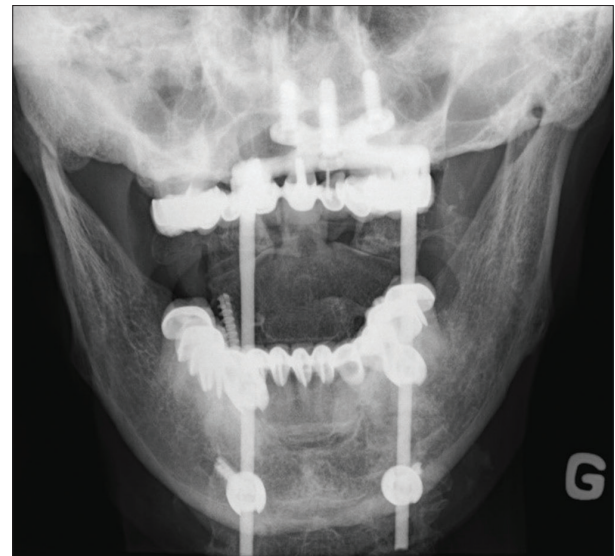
Open mouth view X-ray done postoperatively at 6 months' time showing reduction of C1C2 lateral mass displacement.
